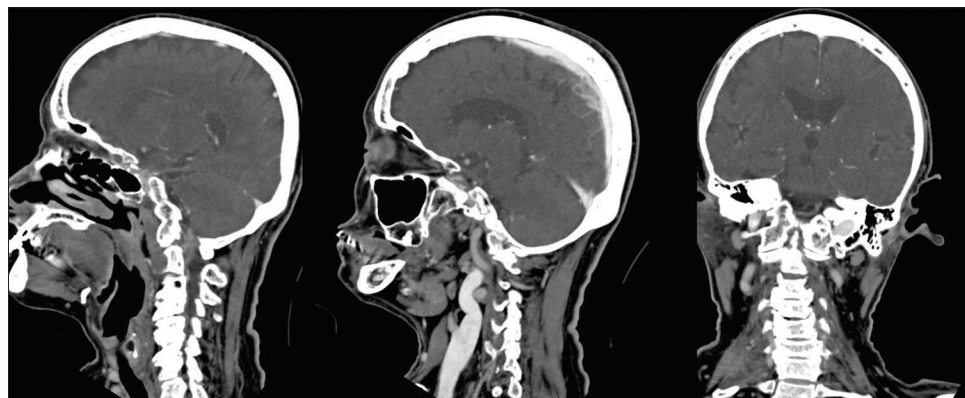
Computed tomography demonstrates an occipito atlas assimilation.
